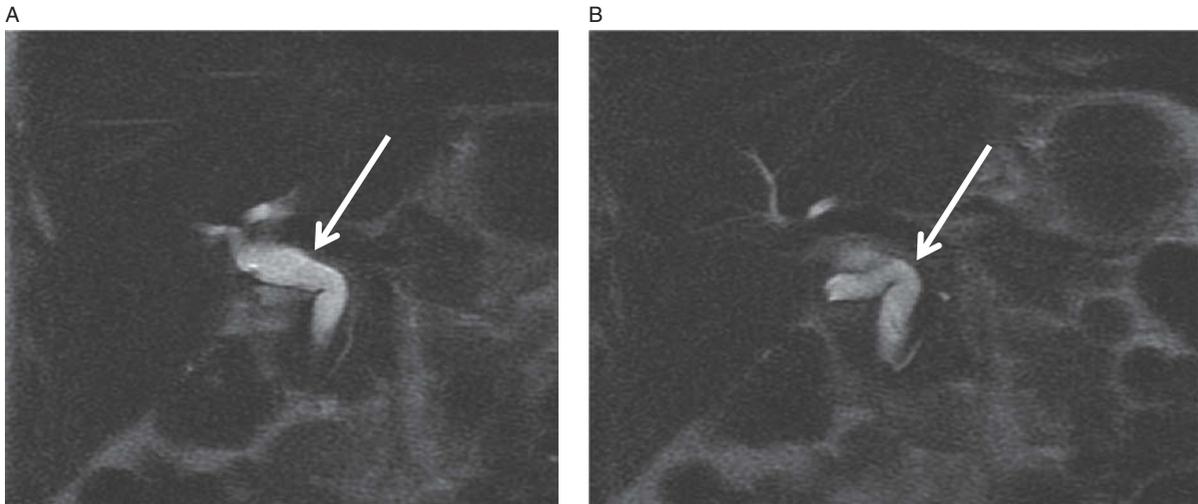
Type I choledochal cyst. Consecutive, coronal T2-weighted images (A, B) showing dilatation of the CBD without definitive etiology (such as stone or stricture). (See arrows). The intrahepatic ducts are normal.
